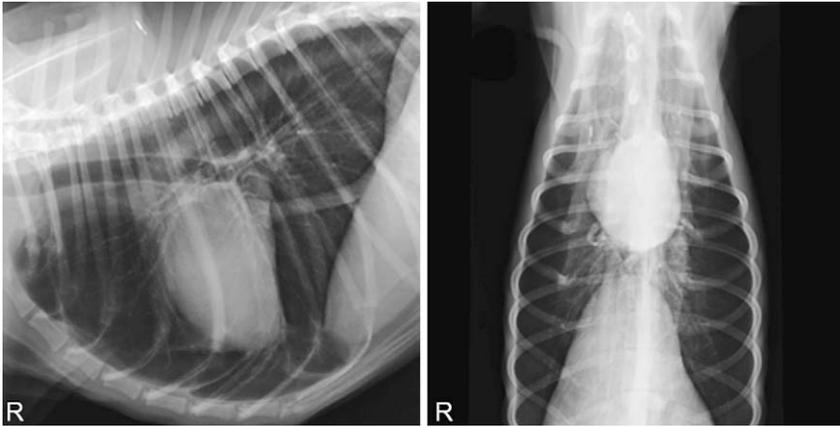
Orthogonal thoracic radiographs of a 5-year-old, F5, standard poodle with hypovolemia. Note that the lungs are fully expanded and reduced in opacity due to small pulmonary blood vessels.
